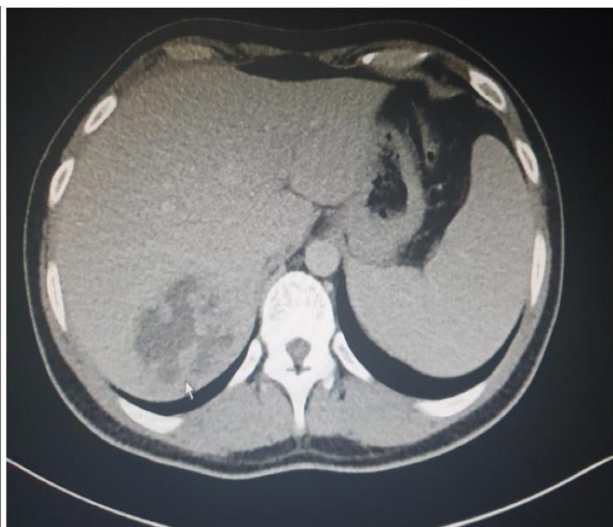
CT scan shows 6 x 5 x 4.5 cm solitary relatively thin-walled multi-loculated abscess
